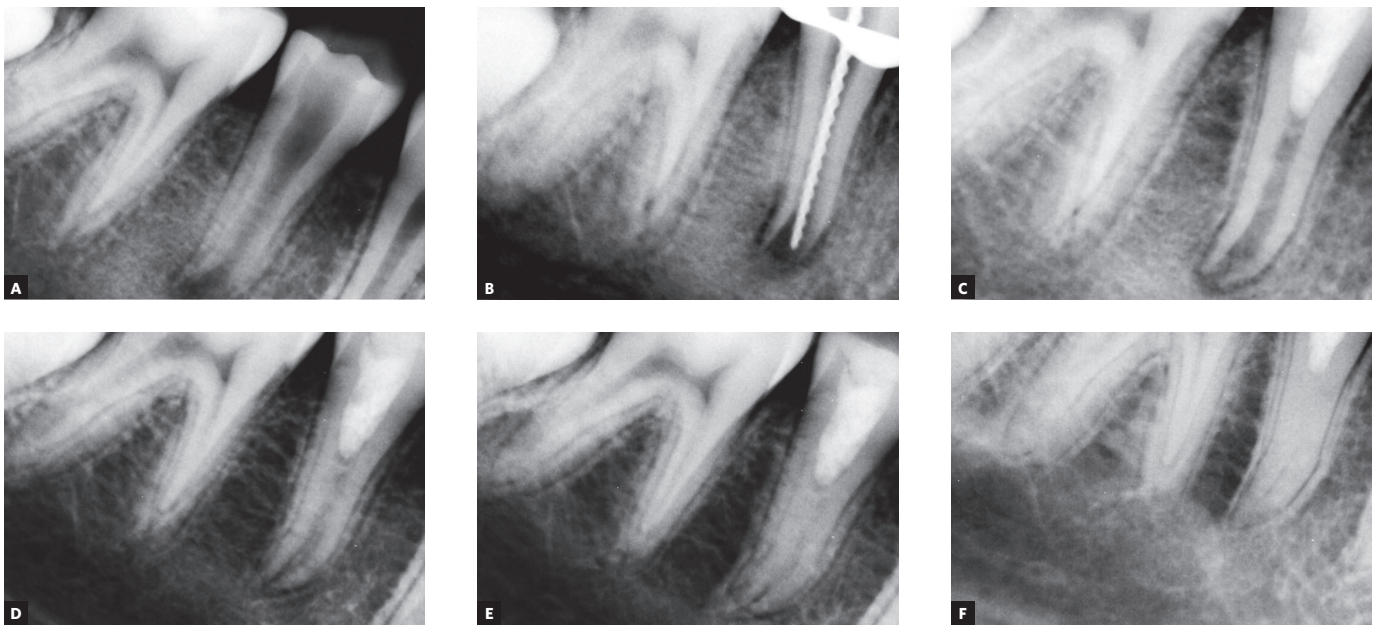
Diagnostic radiograph (A); working length radiograph (B); follow-up radiographies: 3 months (C), 6 months (D), 12 months (E) and 54 months (F).
